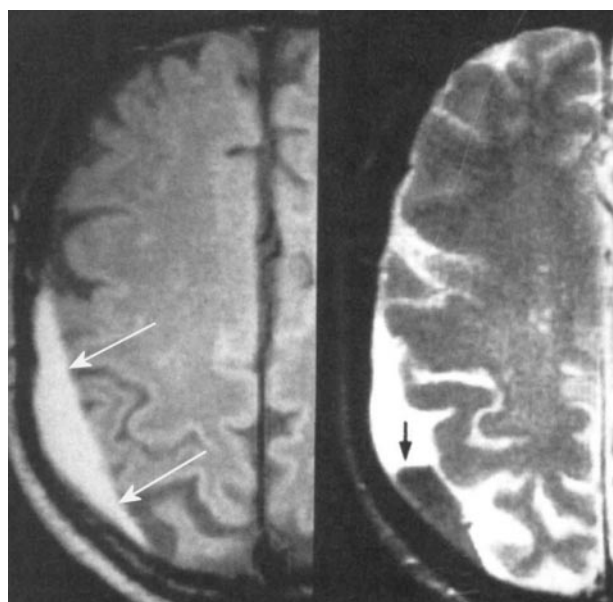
MRI -left proton density subdural right parietal hematoma with hypersemmal area right T2W - hematocrit effect.
